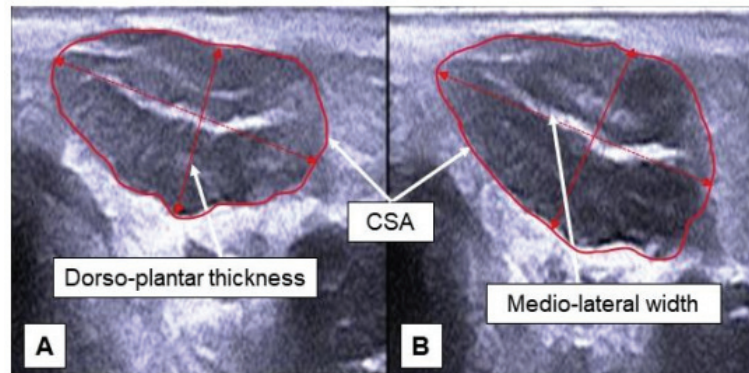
Ultrasonography images of abductor hallucis muscle with short foot exercise (SFE); (A) starting position, (B) ending position.
